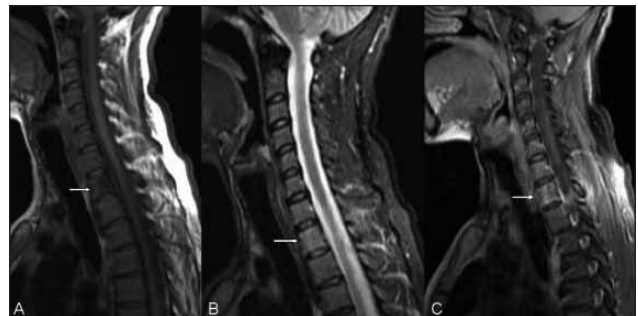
On T1-weighted sagittal MRI, a nodular lesion ~1 cm in size located at the posterior T1 vertebra with hypointensity (white arrow) (A); on T2-weighted sagittal MRI, an intermediate signal intensity (SI) was seen (white arrow) (B); IV contrast (gadolinium) was administered and mild heterogeneous contrast enhancement was seen at the periphery of the lesion (white arrow) (C).
